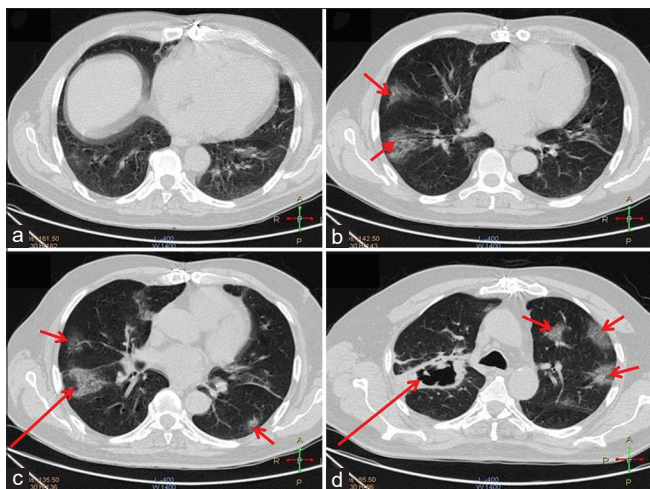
The radiograph of the lung with granulomatosis with polyangiitis. Arrow shows a big pulmonary cavity in the right lung
